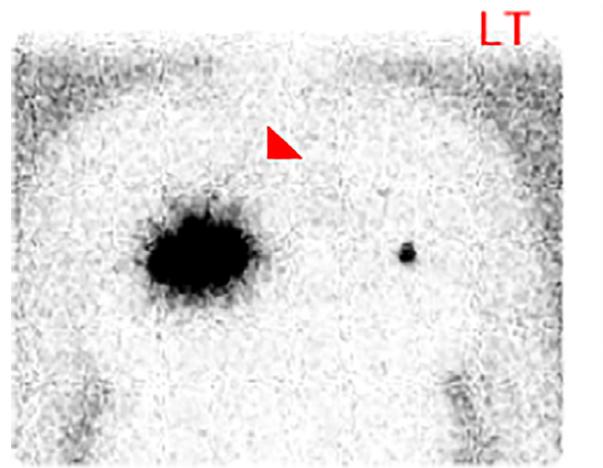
Anterior (229 kV range). Lymphoscintigraphy demonstrated a single radioactive spot at a depth of approximately 3 cm in the contralateral axilla. Arrowhead indicates the injection site.
